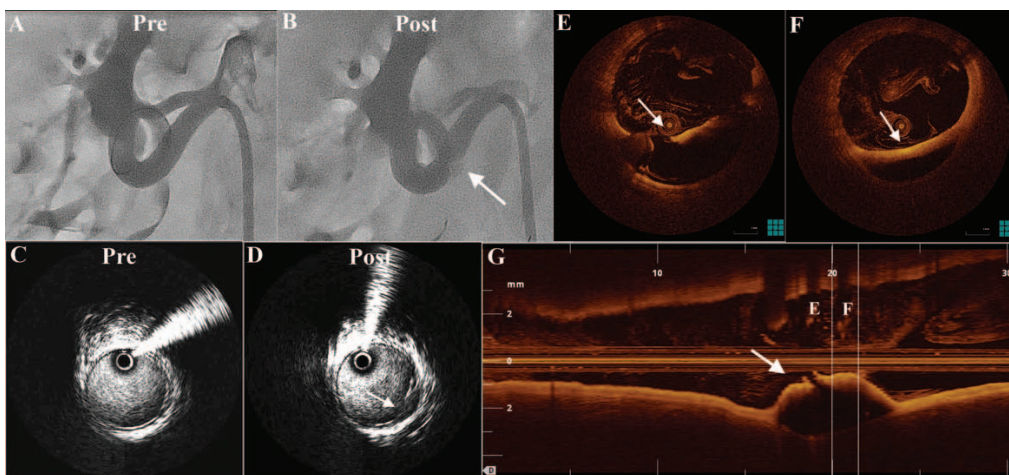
Renal artery dissection visualized by angiography, intravascular ultrasound (IVUS), and optical coherence tomography (OCT). A and B, Renal angiography pre- and postdenervation with the Oneshot system (balloon/artery ratio, 1.16). Angiography shows a contrast deficit (white arrow) indicative of dissection. C and D, Predenervation and postdenervation IVUS images at the contrast deficit site. Postdenervation image shows wall discontinuity with cavity and flap (arrow). E–G, OCT images demonstrating the dissection.
